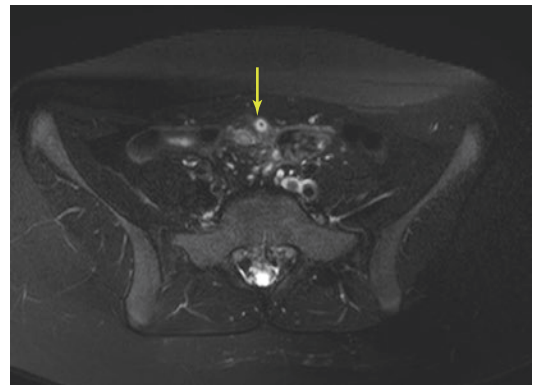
MR imaging Axial T2-weighted fat saturation sequence: Enlarged inflamed appendix (yellow arrow) with a small appendicolith in a 12-year-old obese patient
